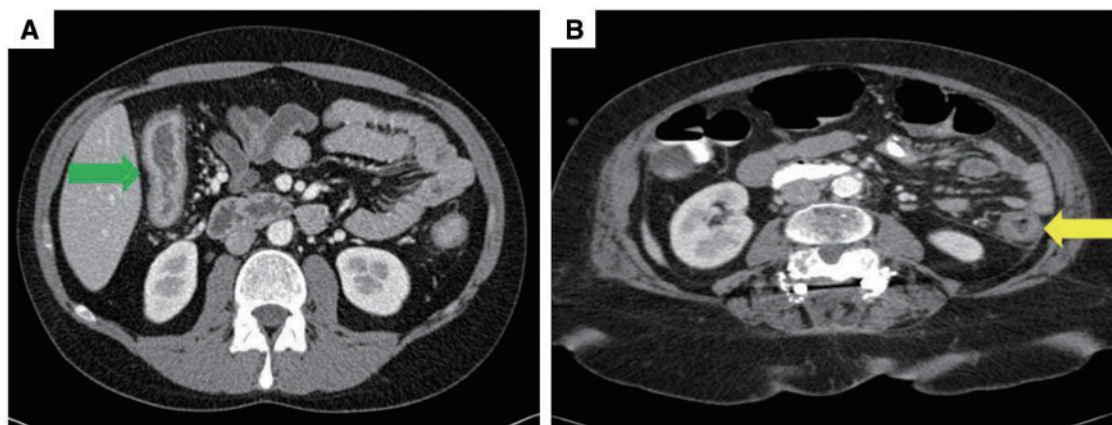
CT scan of abdomen. (A) Crohn's disease with mucosal hyperenhancement (green arrow). (B) Ischemic colitis with the target sign (yellow arrow).
